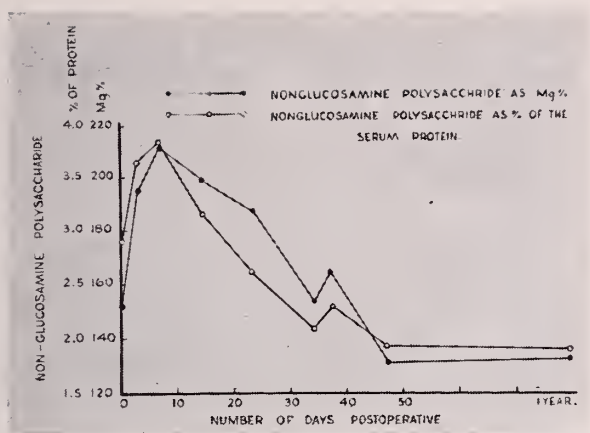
Serial studies of glycoprotein (nonglucosamine polysaccharide) following surgical removal of a carcinoma of the cervix. Following surgical removal on Day 0, the already elevated glycoprotein level became even higher and then fell off, becoming normal about 50 days post operative. Deep x-ray therapy started on the 32nd day was followed by an increase of serum glycoprotein.
